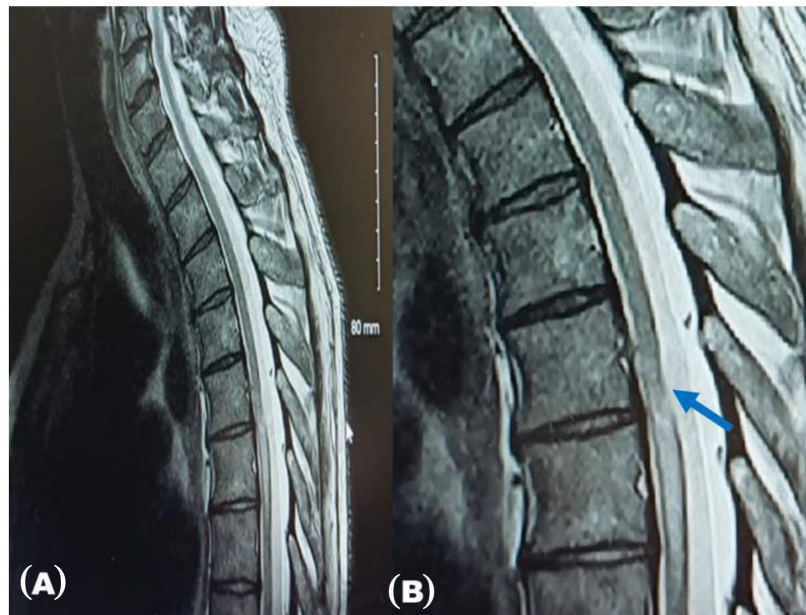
Preoperative sagittal T2-weighted MRI showing myelopathy and syrinx (A) and the arachnoid web as a T2-hypointense band (arrow) (B) [Case 1].
